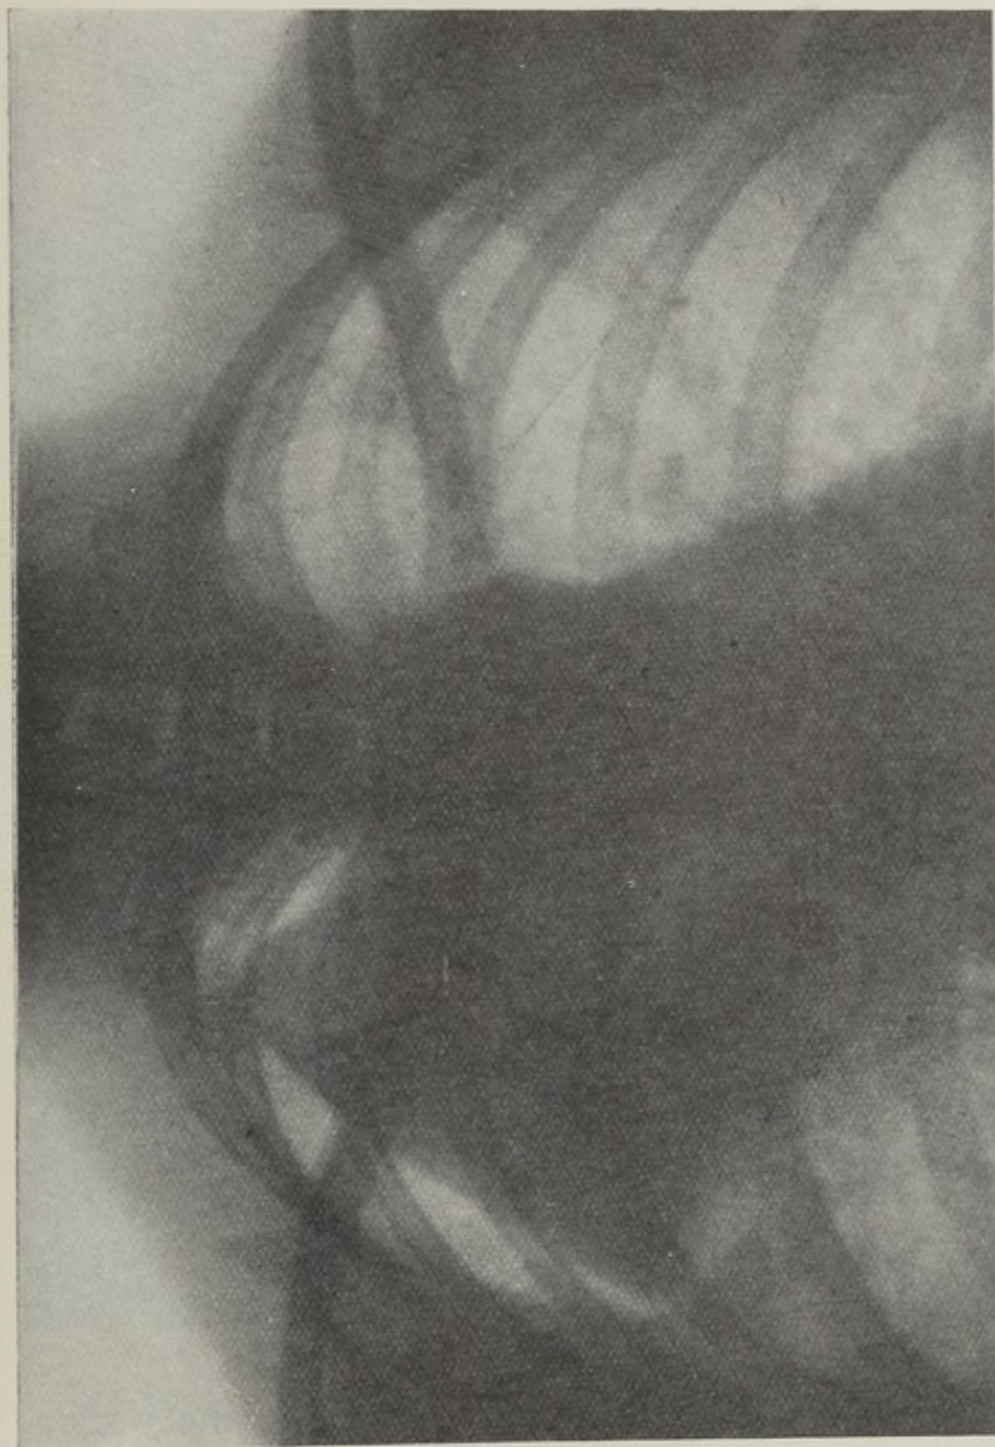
Extensive pulmonary tuberculosis in a woman aged 22. The patient showed no symptoms of tuberculosis, and the disease was only detected on examination. Radiography following the initiation of artificial pneumothorax.
